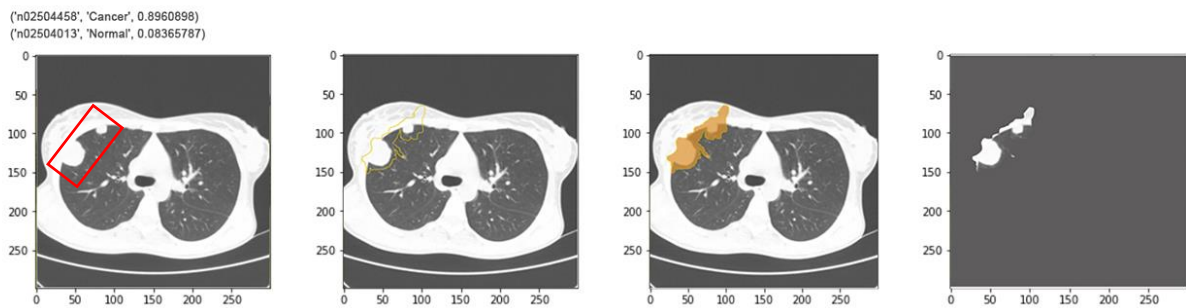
LIME result of CT image with a model of DenseNet169
